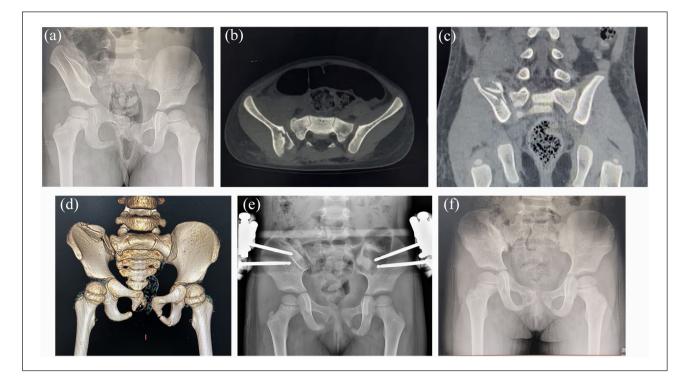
A five-year-old girl with a type CI pelvis fracture as a result of a motor vehicle accident. (a) A preoperative anteroposterior pelvic radiograph reveals sacroiliac joint dislocation and pubic symphysis separation. The preoperative pelvic asymmetry is 2.0 cm. (b–d) Pelvic computed tomography image and three-dimensional reconstruction show fracture and dislocation of the sacroiliac joint. (e) Postoperative pelvic anteroposterior radiograph indicates satisfactory reduction. The postoperative pelvic asymmetry is 0.8 cm. (f) An anteroposterior pelvic radiograph obtained 4 years after surgery is shown.
